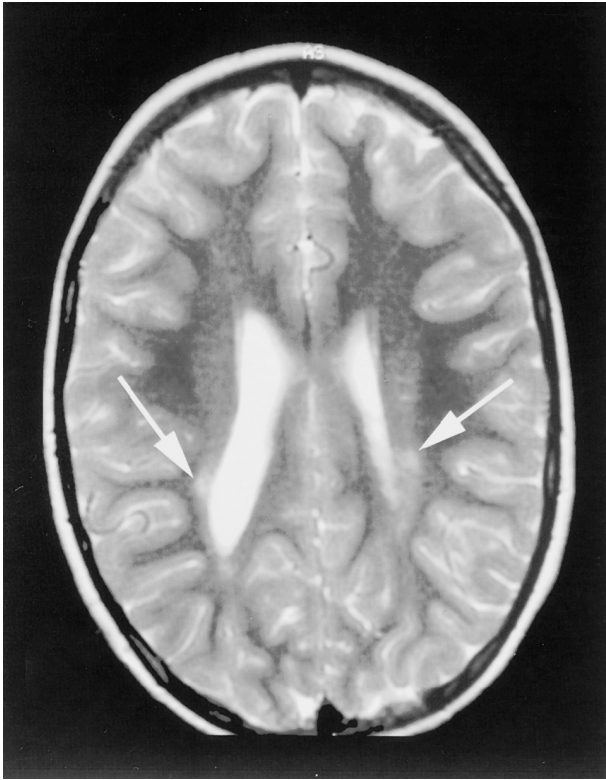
This MRI (T-weighted image) is from a 5-year-old girl, born at gestational age 32 weeks, with an uneventful neonatal period, who presented to the pediatric ophthalmologist with early-onset esotropia. At 5 years she had bilateral crowding and a visual acuity with linear optotypes of 20/60 RE, 20/40 LE. Her intellectual development was normal and she did not have cerebral palsy. Note in this image through centrum semiovale subtle evidence of abnormally increased signal in white matter indicating gliosis (arrows). These findings are consistent with very mild PVL. (Courtesy of Dr. Olof Flodmark.)
